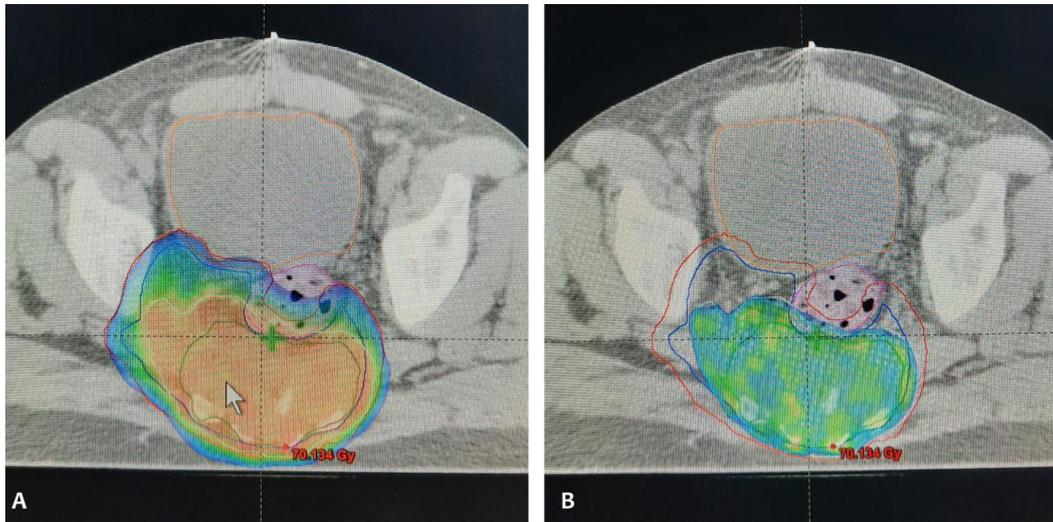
Axial CT-scan images from treatment planning system, showing dose distribution in the PTV1 (A) and PTV2 (B)
